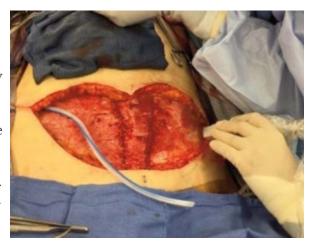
Correct placement of ultrasound probe for intraoperative technique
